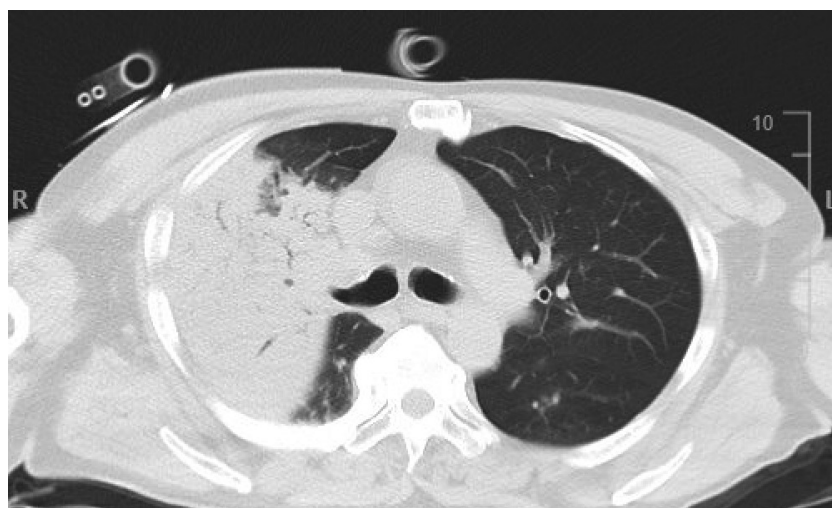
Axial chest computed tomography on emergency department
